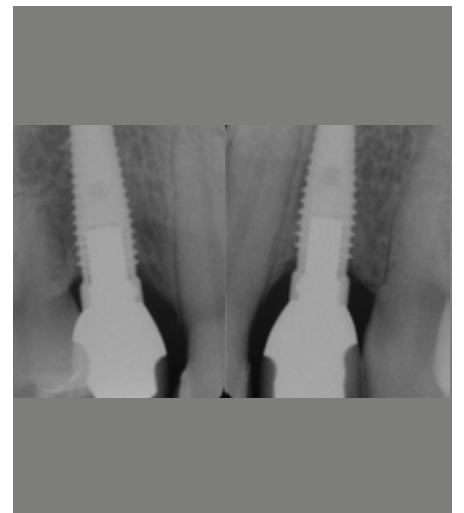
Radiographic outcome at eight-year follow-up.
